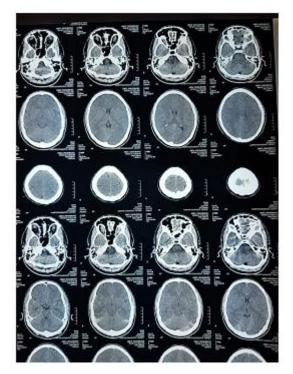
CT Brain showing; right temporoparietal cortical enhancement.
